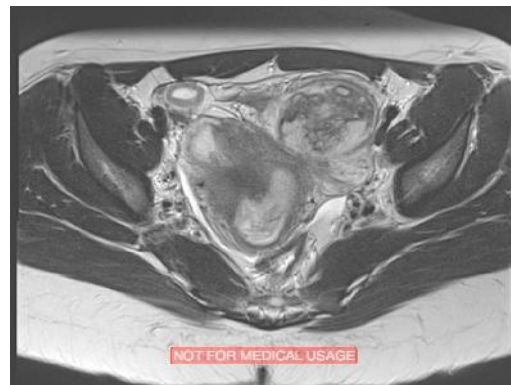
Magnetic resonance imaging in axial section and T2-weighting, without fat saturation, showing enlarged gravid uterus, associated with mass, heterogeneous in the left adnexal region. Patient remained stable, performing sequential ultrasound for follow-up, showing stability of characteristics and size of the adnexal mass, with normal development of the intrauterine fetus, with consequent term child-birth, by cesarean section.
